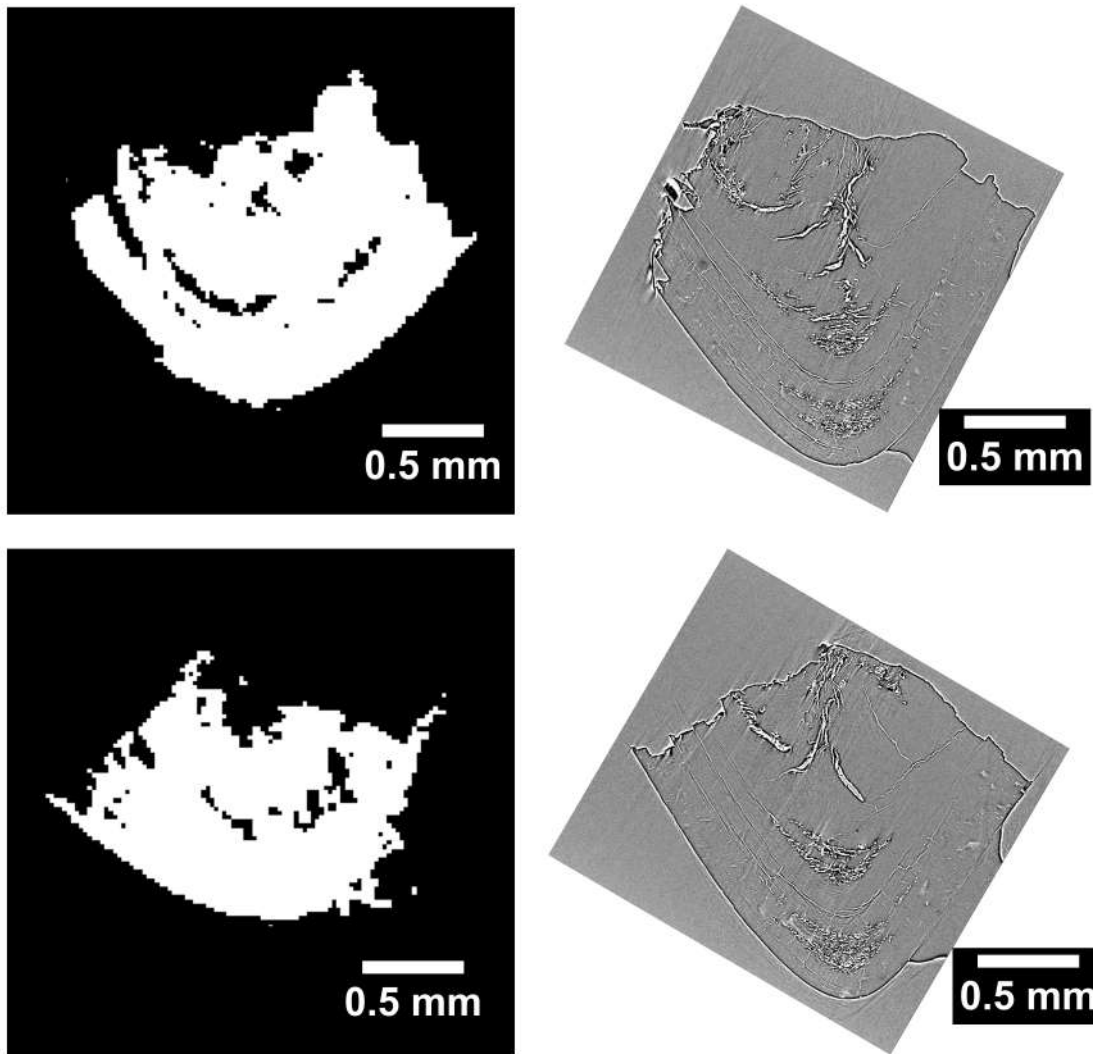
On the left side, two slices of the binary reconstructed volume with the Tensor Tomography technique. On the right side, two slices of the Computed Tomography reconstruction, rotated to approximately match the alignment of the Tensor Tomography reconstructed volume.
